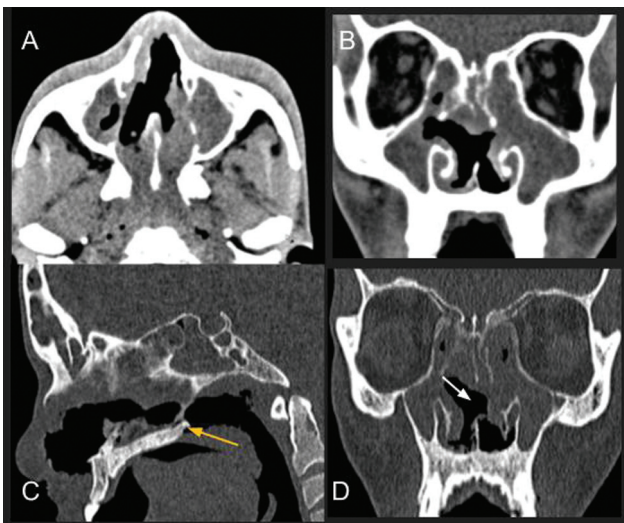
Soft tissue (A, B) and bone window computed tomography (CT) images (C, D) of a 30-year-old male with on- and off-nasal bleeding for 2 months show extensive sinonasal mass-like soft tissue thickening in the nasal cavity and maxillary antrum extending to the nasal skin and subcutaneous tissue with septal and turbinate bony destruction (white arrow in D), roomy nasal cavities, and hard palate typically spared (yellow arrow in C). Biopsy-proven natural killer (NK) cell lymphoma.
